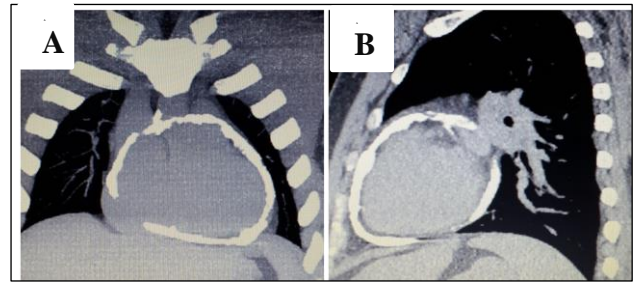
Non-contrast computed tomography (CT) reconstructed images in coronal (A) and sagittal (B) planes show thick, calcified pericardium around the heart.
